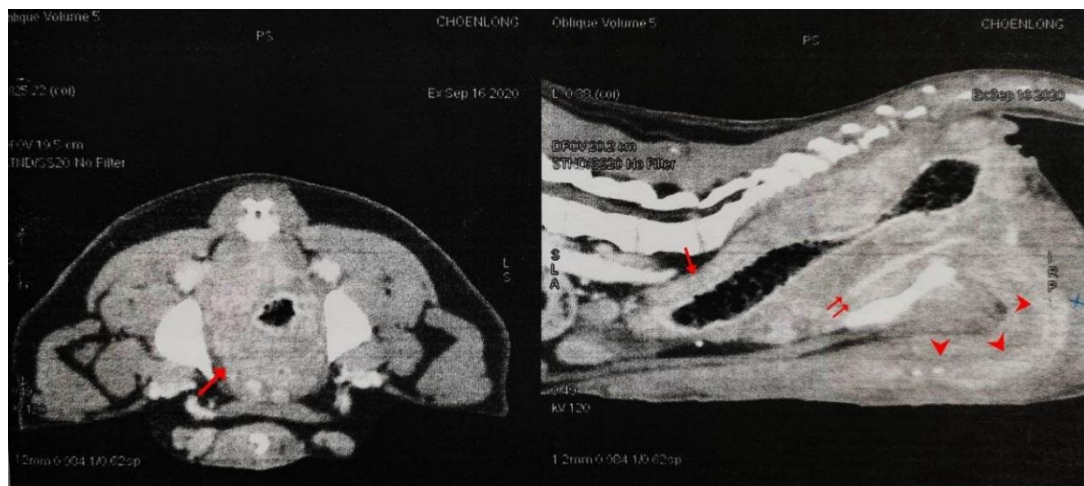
CT scan revealed marked thickening of colonic wall (arrow tail) with ventrally deviated urethra (double arrow) and penis (arrow head).
